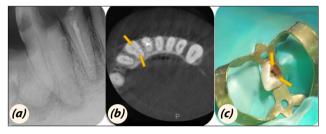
(a) Preoperative radiograph (b) Preoperative Cone beam computed tomography (CBCT) coronal scan showing two separate canals (c) Clinical photograph after access opening showing two distinct canals opening.
